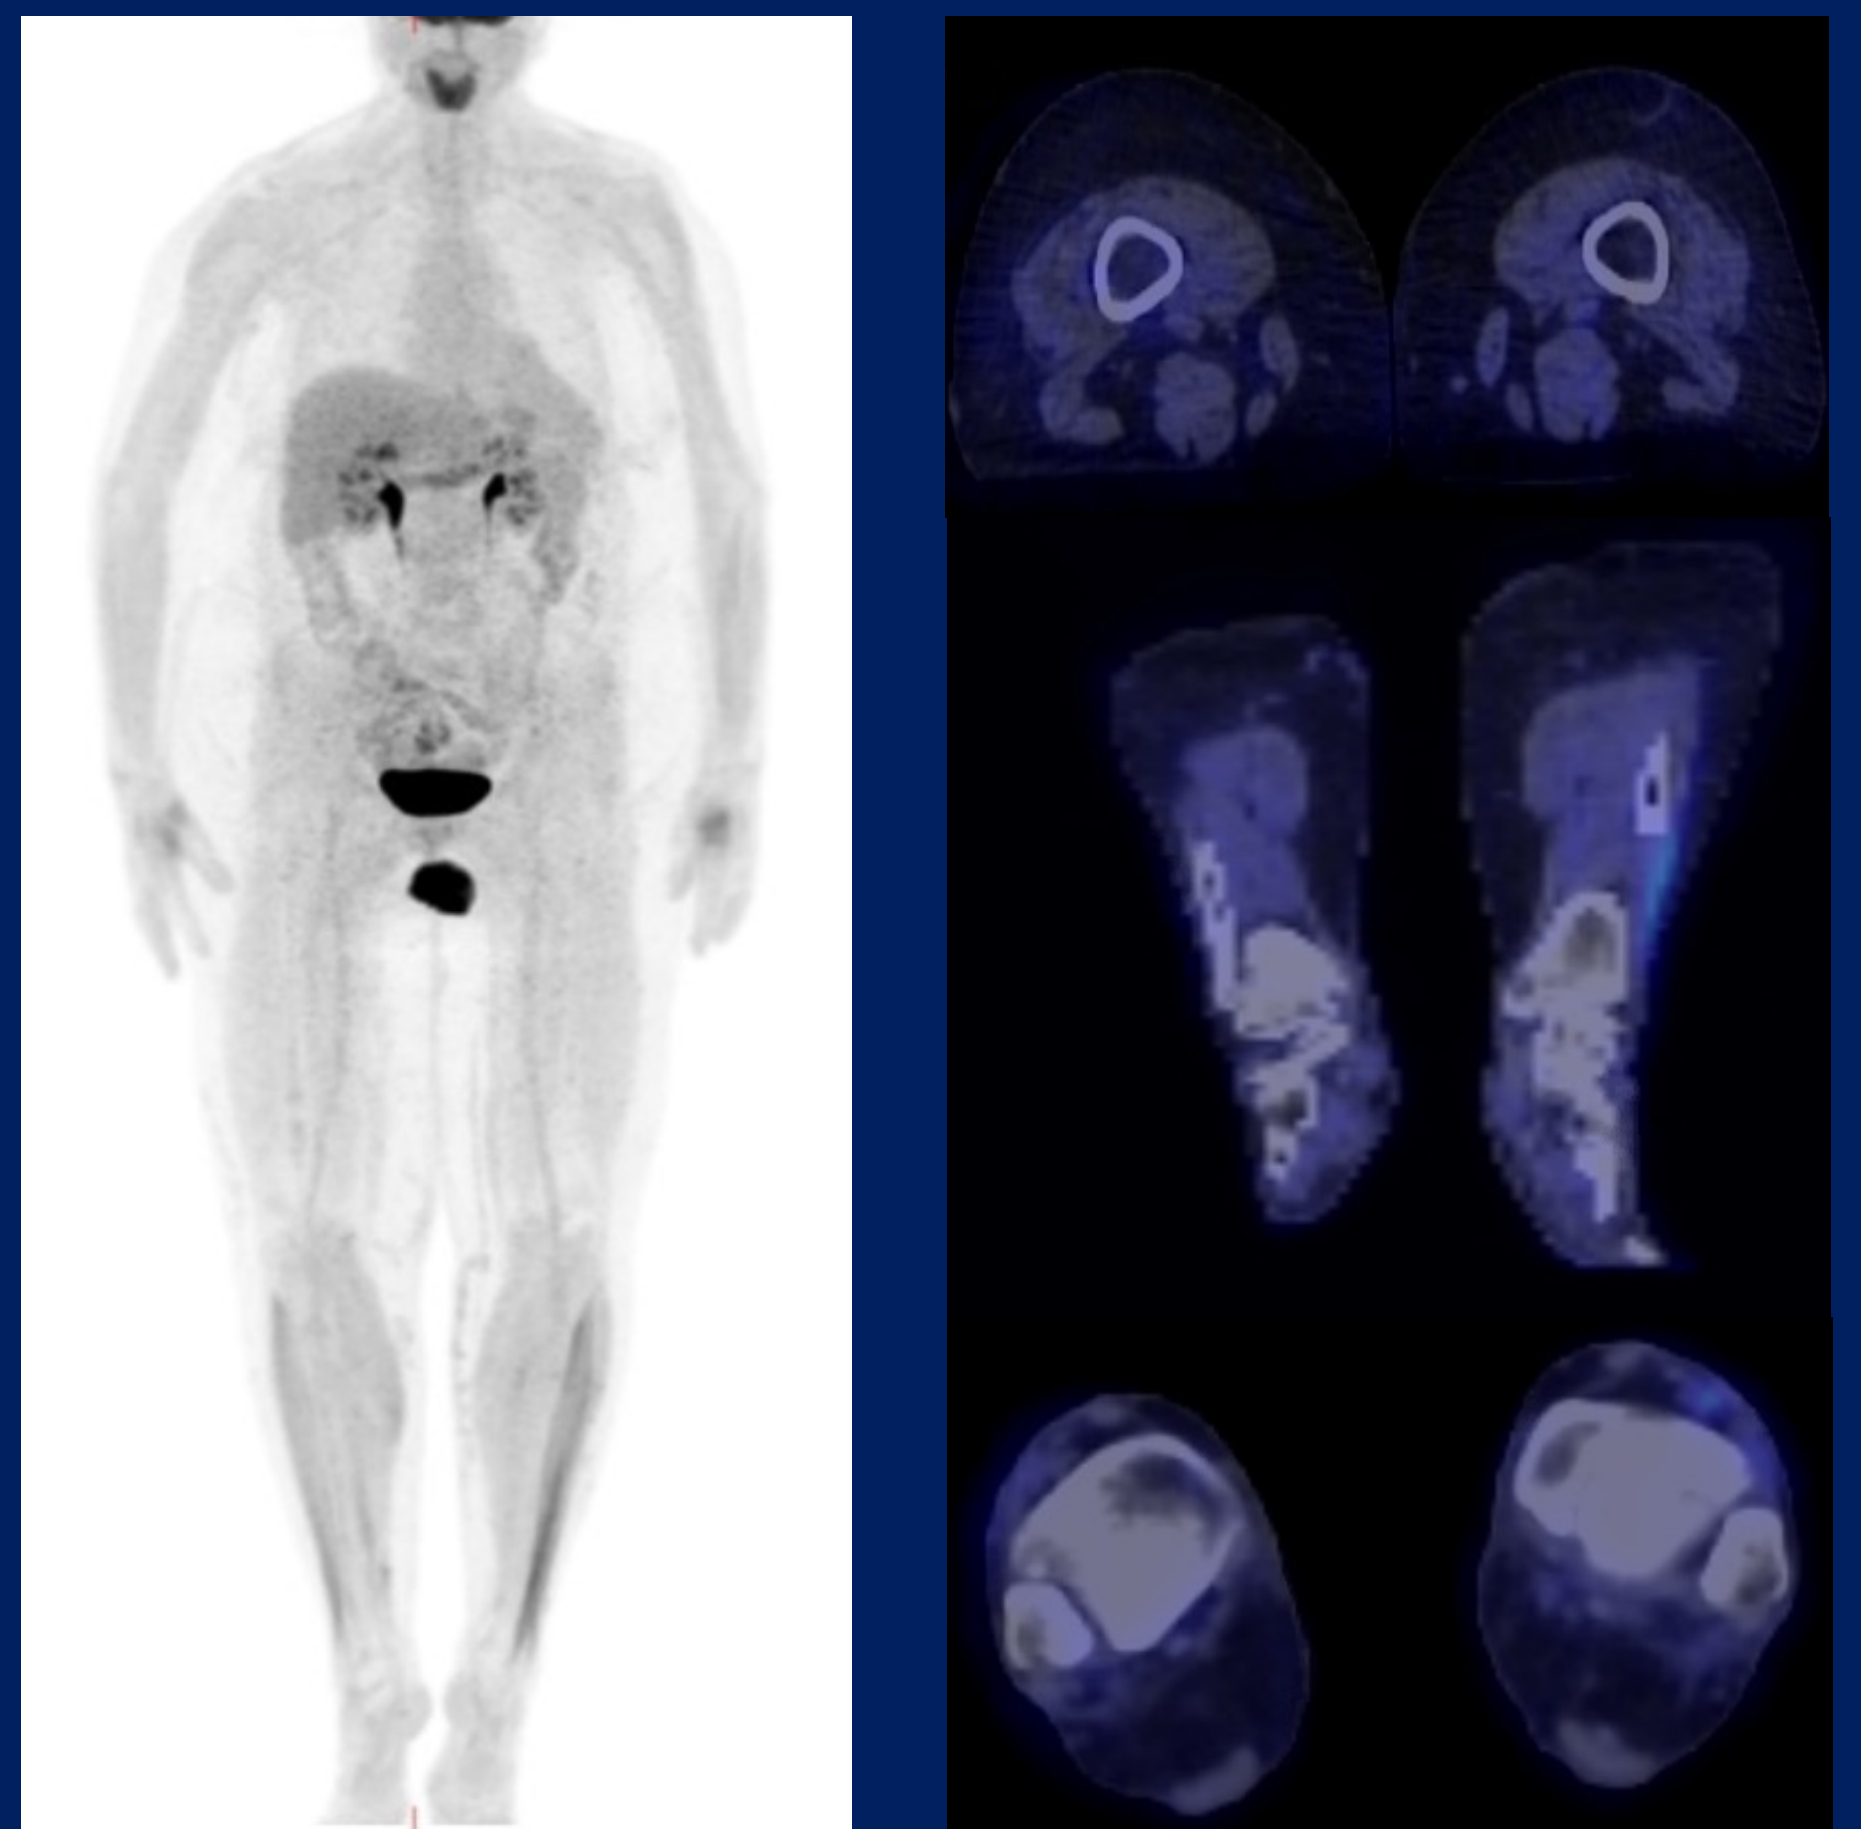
Sep 2021 whole body PET/CT showing maintained complete response after 15 cycles of Brentuximab Vedotin.
